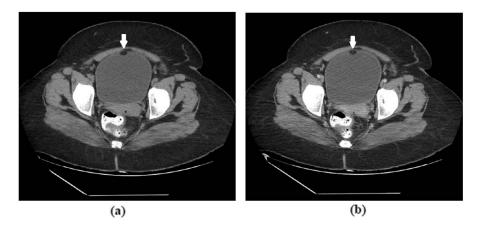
(a) Non-contrast pelvic computed tomography image showing an ovoid, smoothly marginated, markedly hypodense mass lesion indenting the lumen in the anterior bladder wall. (b) No enhancement in the contrast examination.
